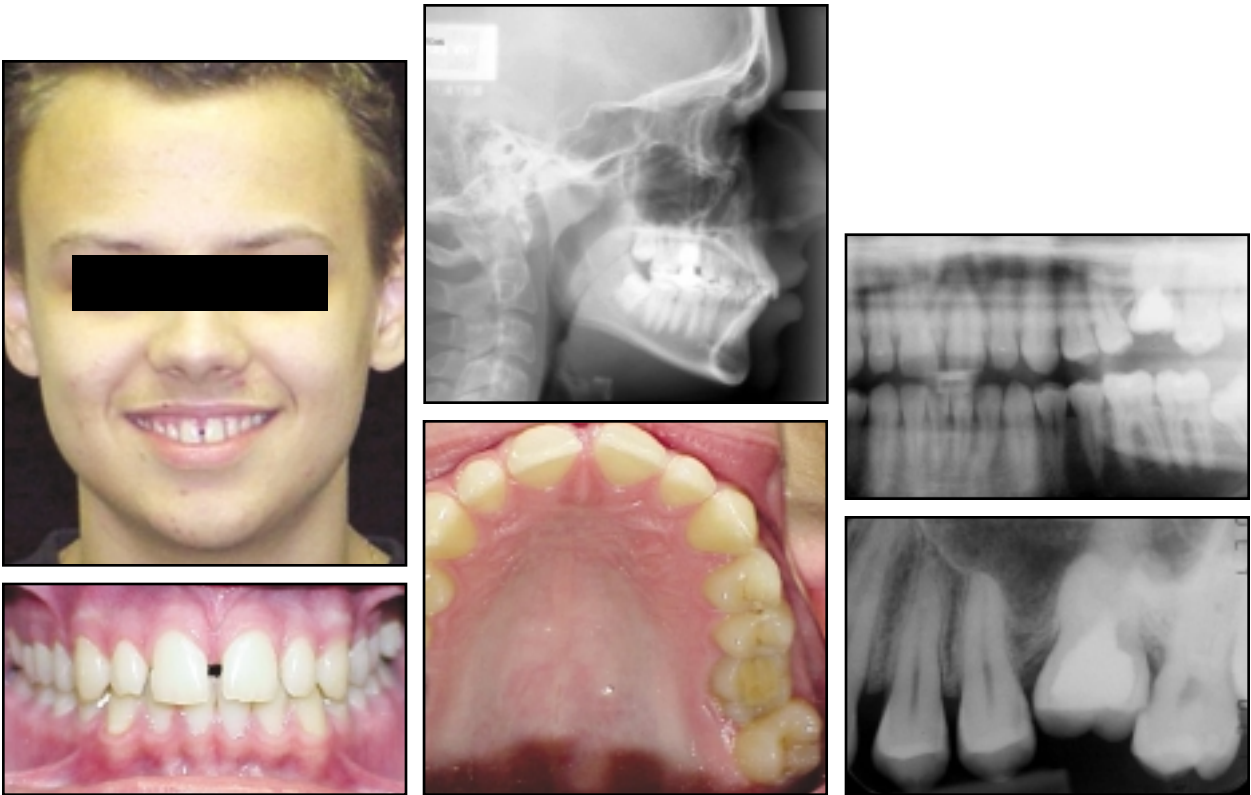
Case 2. 16-year-old male with ankylosed maxillary left first permanent molar before treatment. Radiographs show infraocclusion of molar and obliteration of periodontal ligament.
